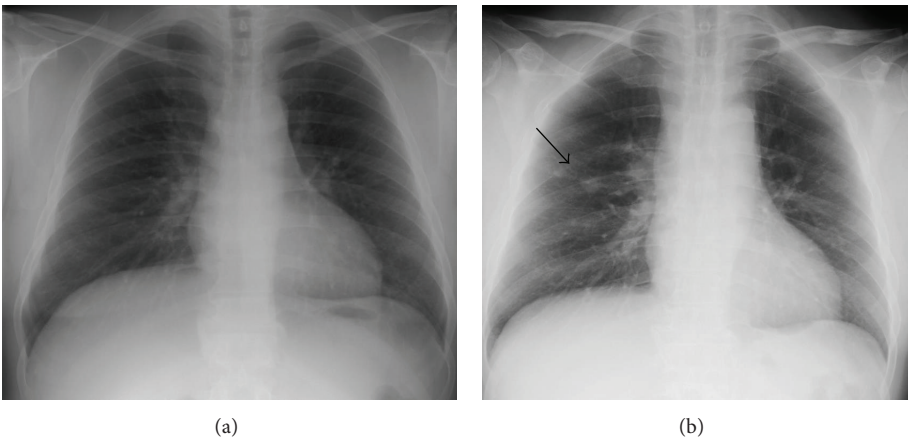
Chest X-ray at the onset of DM (a). Chest X-ray at the lung cancer diagnoses revealing a small tumor in the right middle lung field 7 years after the onset of DM (b).
